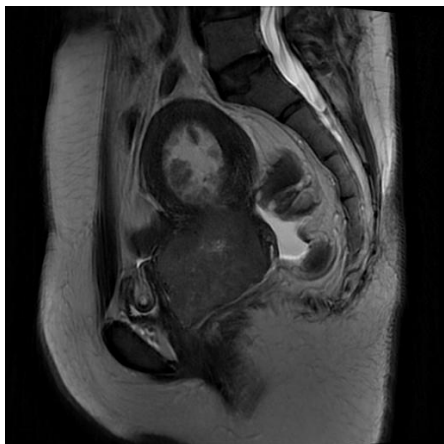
Magnetic resonance imaging showing lobulated swelling of non-homogenous signal intensity measuring approximately 61.3 mm × 59.1 mm × 55.8 mm, with few areas of tiny cystic degeneration involving the uterine cervix and the lower uterine segment to a lesser extent
